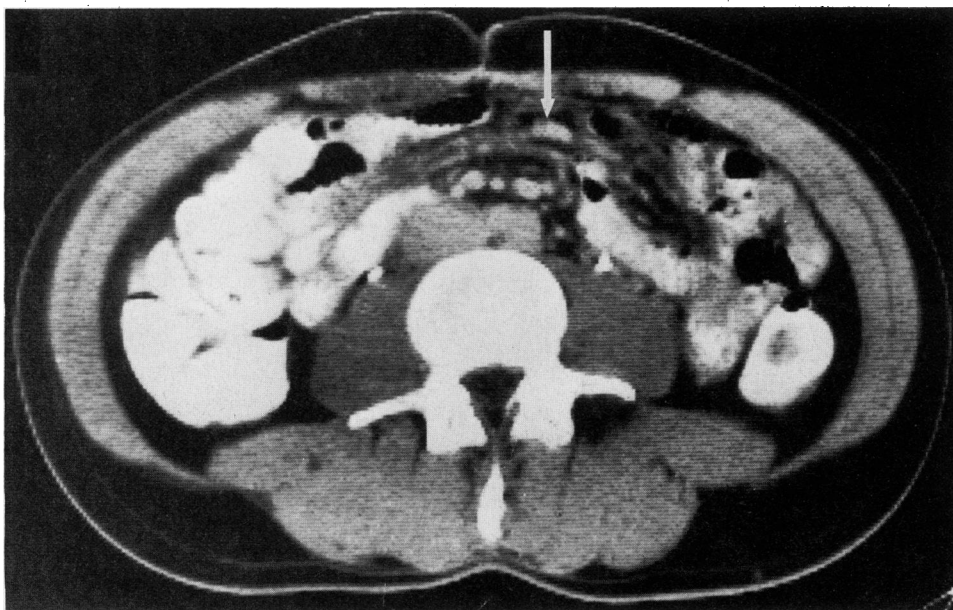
A follow-up computed tomographic scan shows resolution of the mesenteric mass. Residual mesenteric thickening is seen (arrow).
